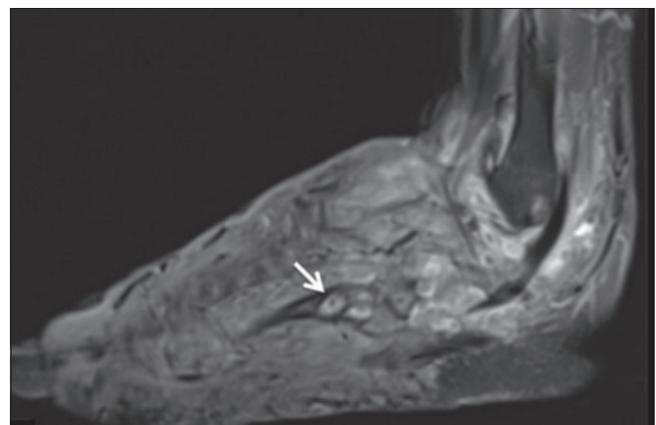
MRI T2 show inflammatory changes with multiple soft tissue and osseous small hyperintense lesions with peripheral hypointense rim corresponding to mycetoma grains (yellow arrows). Few of them showing “dot in circle” sign (thicker white arrow).
